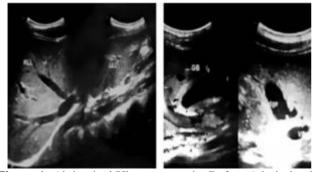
Abdominal Ultrasonography Before Admission in Wangaya Regional General Hospital.
